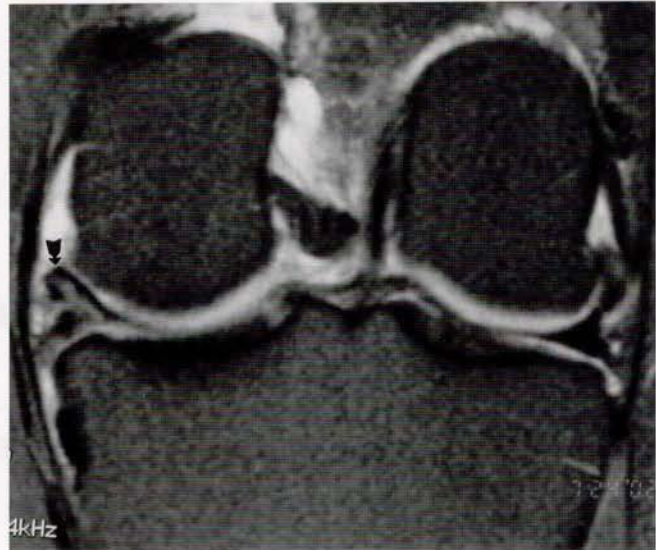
Magnetic resonance imaging scan of a typical meniscal tear. The arrow points to the medial meniscus with a complex tear pattern.
